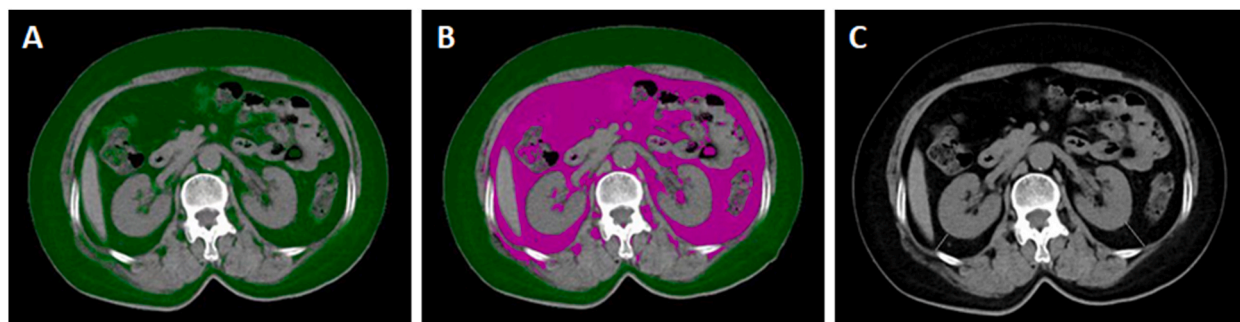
Definition of the adipose tissue in CT cross-sectional image with the threshold method. A. total abdominal fat (green); B. subcutaneous adipose tissue (green) and visceral adipose tissue (purple); and c. Para-perirenal fat thickness (white line).
